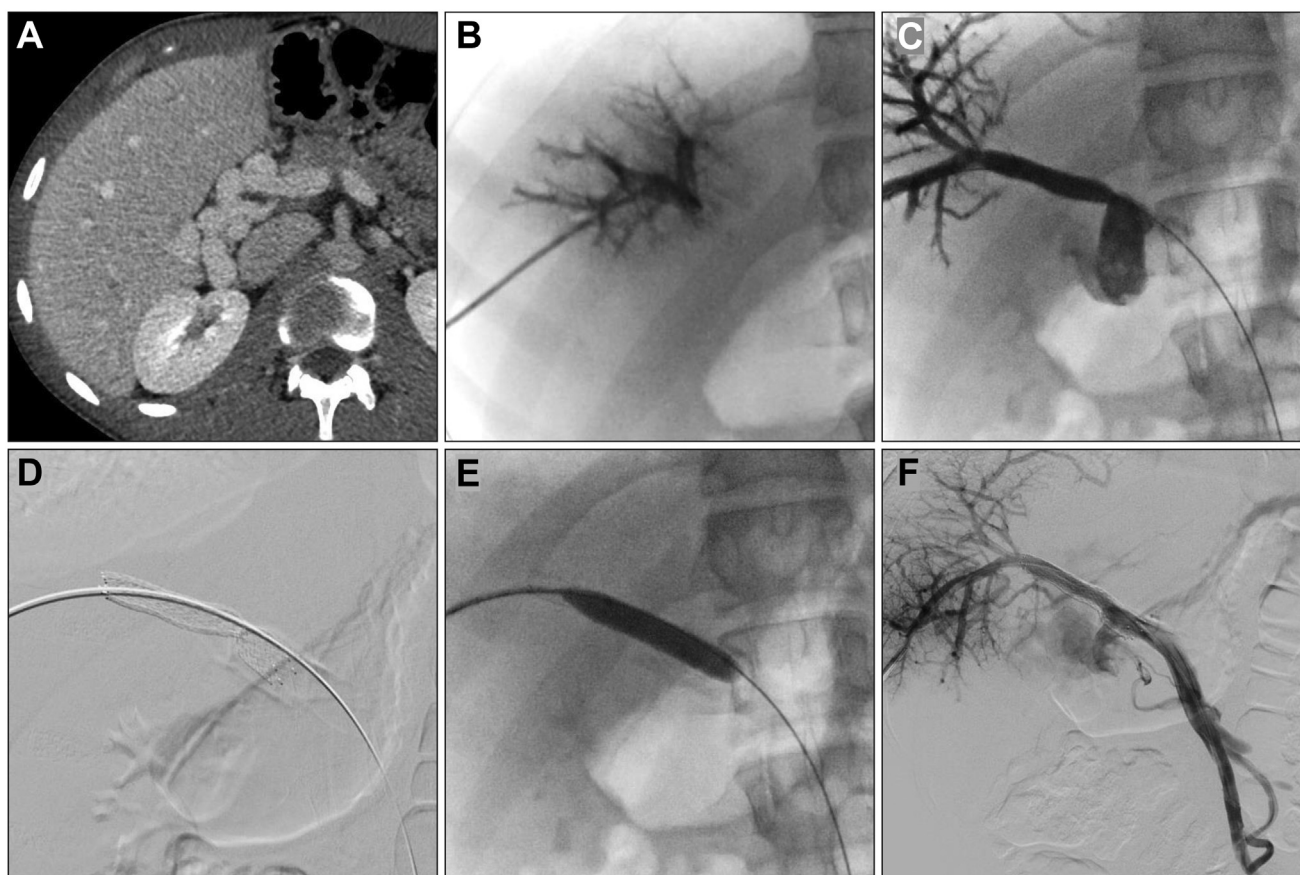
19-year-old man with chronic portal vein thrombosis and cavernous transformation undergoing portal vein recanalisation. (A) Pre-procedural contrast-enhanced CT shows cavernous transformation of the main portal vein. Recanalisation procedure consisting of (B) catheterisation of the segment IV portal vein branch, (C) catheterisation of the portal vein and superior mesenteric vein through the portal cavernoma, (D) stent placement, (E) dilatation of the stent at 10 mm, and (F) final portogram.
